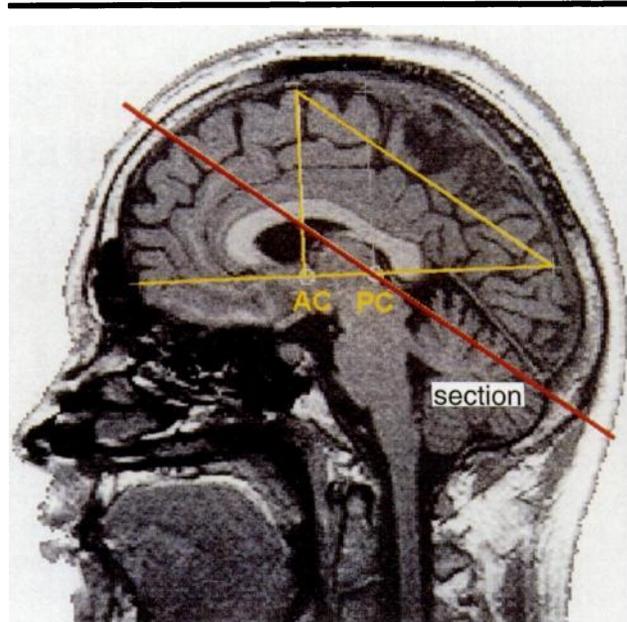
Spin-echo MR image (300/15) demonstrates the section position in the midline sagittal plane. The red line represents the single section used in the functional MR imaging examination. The yellow lines are subsidiary lines used during the planning of the final section.
